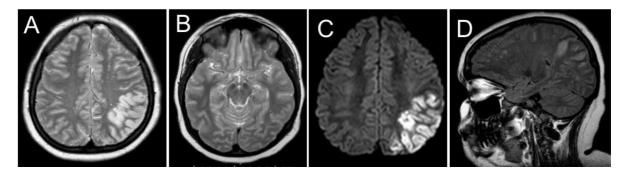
(A, B) T2 weighted, axial MRI brain showed ischaemic changes left parietal region, with fragile blood vessels (asterisks) visible in the basal cisterns. (C) DWI sequence axial MRI brain showed left parietal acute infarct. (D) FLAIR sequence sagittal MRI brain showed multiple areas of ischaemic changes.
